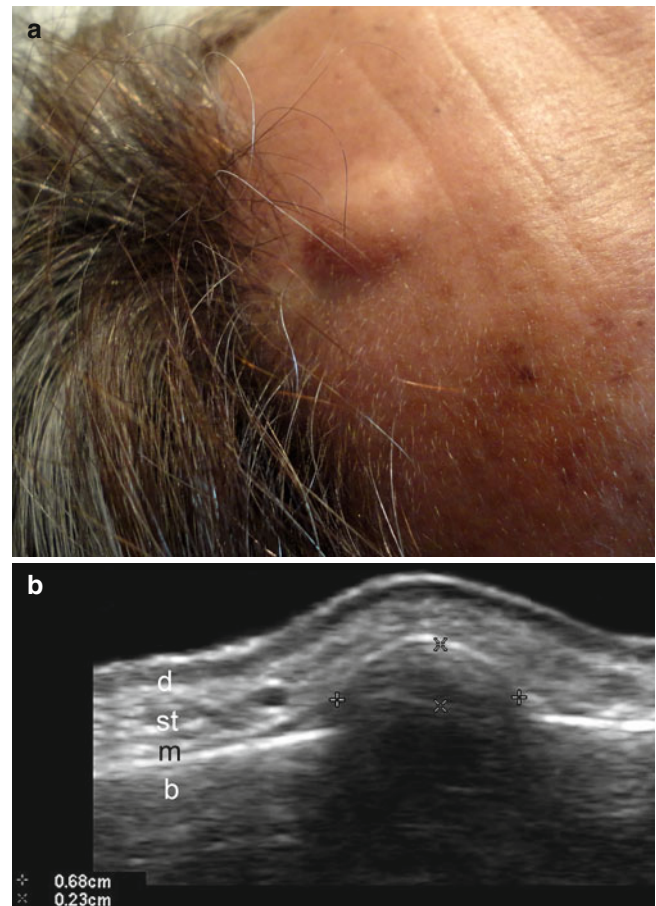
(a, b) Osteoma cutis. (a) Clinical image shows a lump in the frontal region. (b) Grey scale ultrasound image (transverse view) demonstrates a 6.8 mm (wide) \times 2.3 mm (deep) fusiform oval-shaped hyperechoic structure located between the epicranium muscle and the bony margin of the skull. The structure produces acoustic shadowing artifact. *Abbreviations:* *d* dermis, *st* subcutaneous tissue, *m* epicranium muscle, *b* bony margin of the skull
